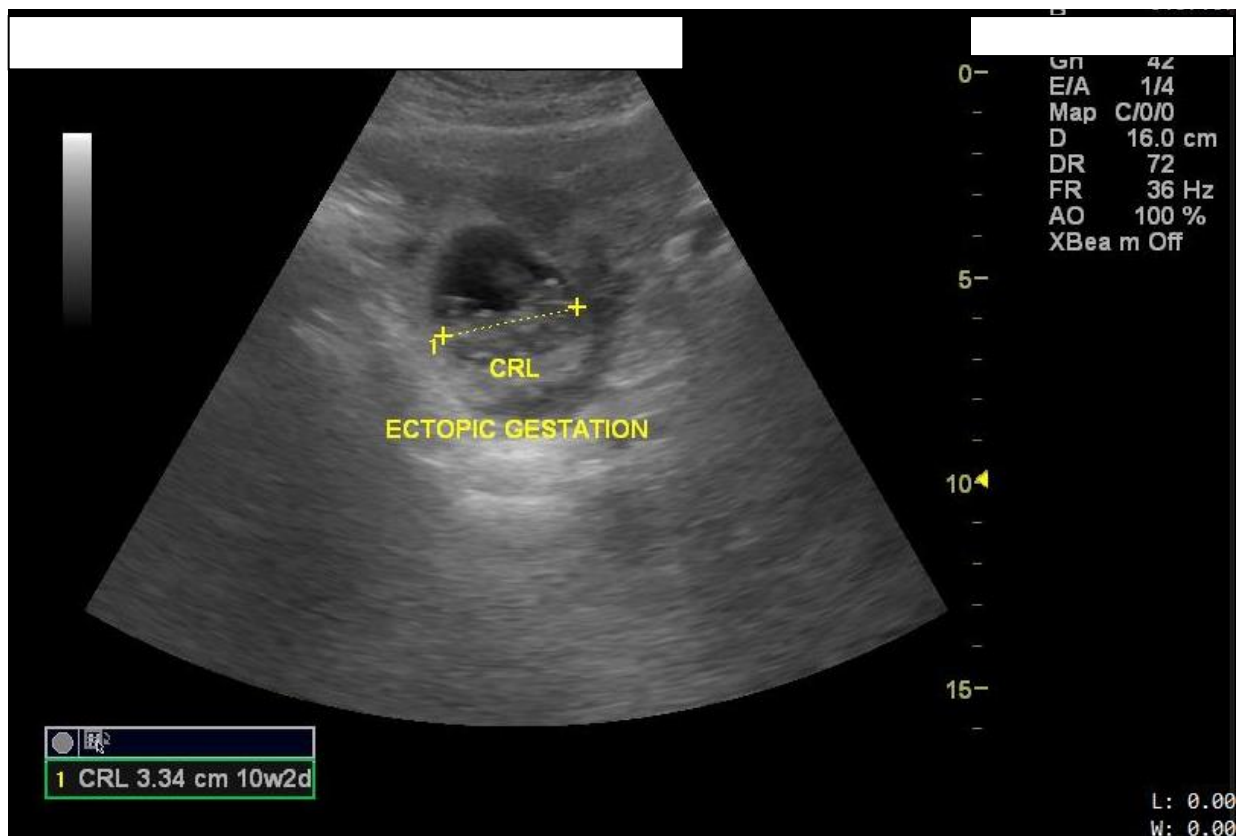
Pelvic ultrasound showing the fetal crown rump length (CRL) measurement of 3.34 cm with gestational age of 10weeks 2days.
